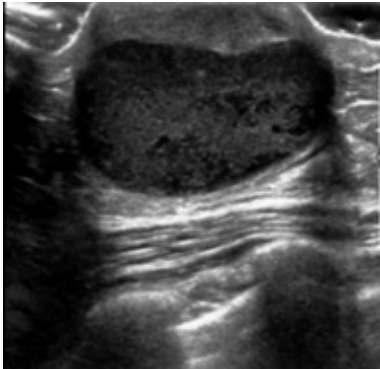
Ultrasound was conducted and showed solid, reasonably well circumscribed ovoid mass in the immediate subareolar right breast measuring 3.5 x 1.5cm.
